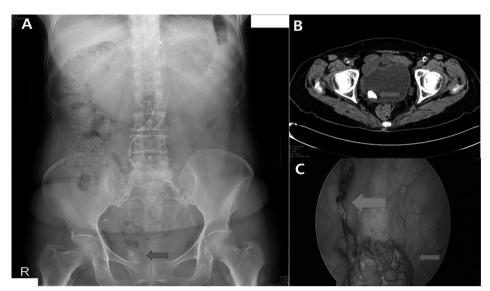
Preoperative radiologic study showing a radioopaque and round bladder stone in the right side of the pelvic cavity in (A) KUB and (B) abdominal CT. On cystoscopic examination, a bright yellow stone is identified in the right posterior wall of the bladder, and it is suspended and surrounded by suture material passing through the right posterior bladder wall (C).
